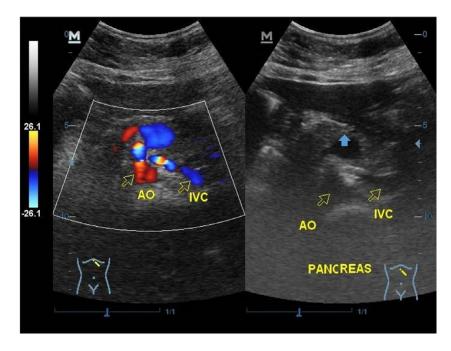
Sonograms of the epigastric region in the transverse plane showing a left-sided pancreatic head (blue arrow) and the anatomical reversal of the abdominal great vessels on the color Doppler image.
